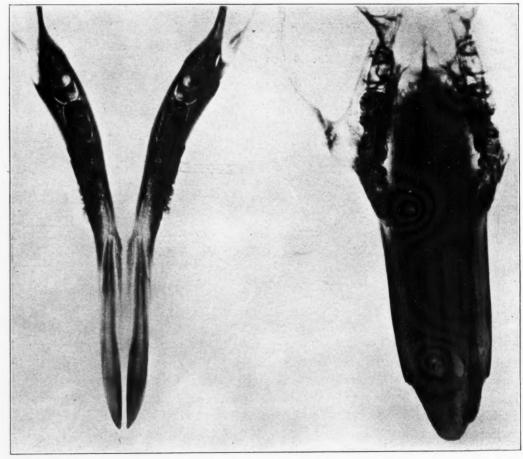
Radiographs of mandible and maxillæ of kangaroo.
